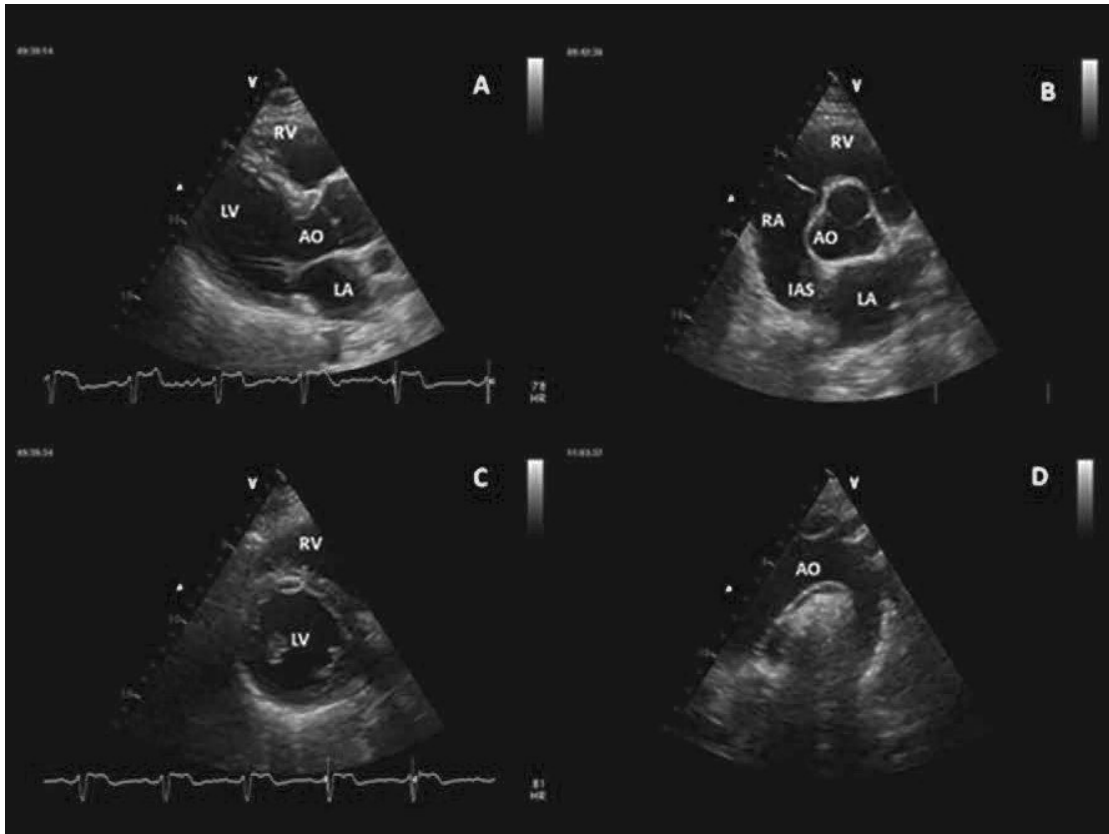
Parasternal long-axis (A), short axis (B, C), and suprasternal windows (D) showing left and right chambers and aortic valve and arch. *LV*, left ventricle; *LA*, left atrium; *RV*, right ventricle; *RA*, right atrium; *AO*, aorta; *IAS*, interatrial septum.
